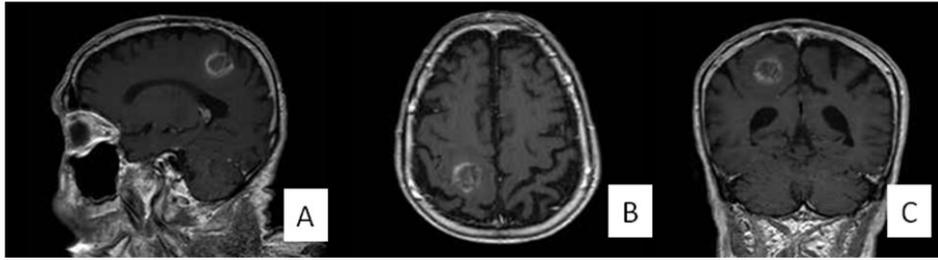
Sagittal (A), axial (B) and coronal (C) T1-weighted MR scan images confirming an heterogenous, partially hemorrhagic lesion with faint contrast enhancement.
